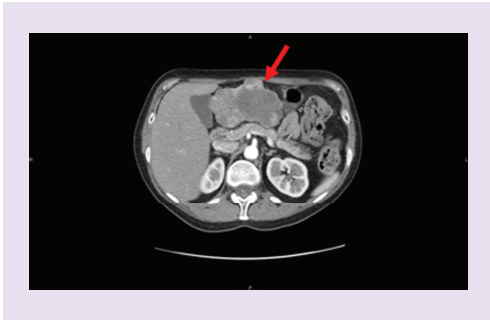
CT scan showing stable disease after two cycles (March 2012).
